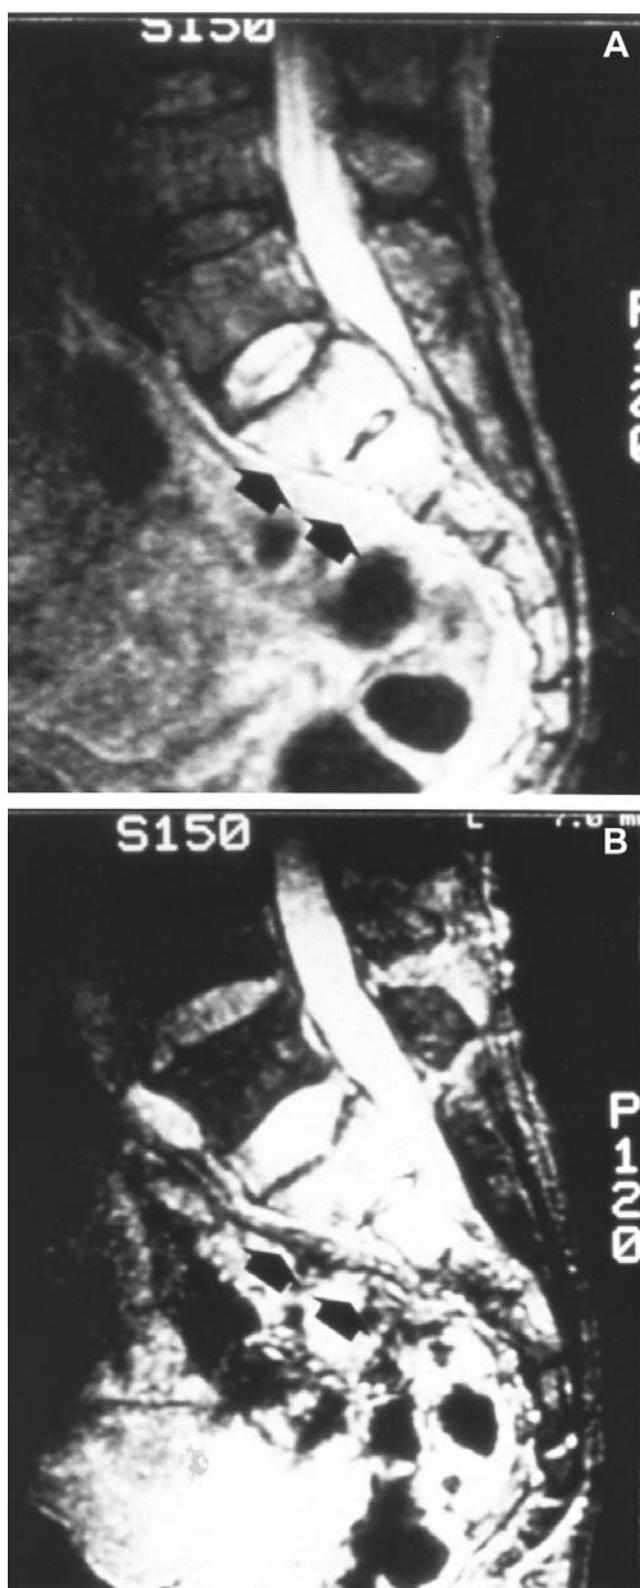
MRI findings before and after chemotherapy. A. Tumor of the sacrum with a soft tissue mass. B. The soft tissue mass disappeared after three courses of chemotherapy. Arrows indicate the soft tissue mass.
